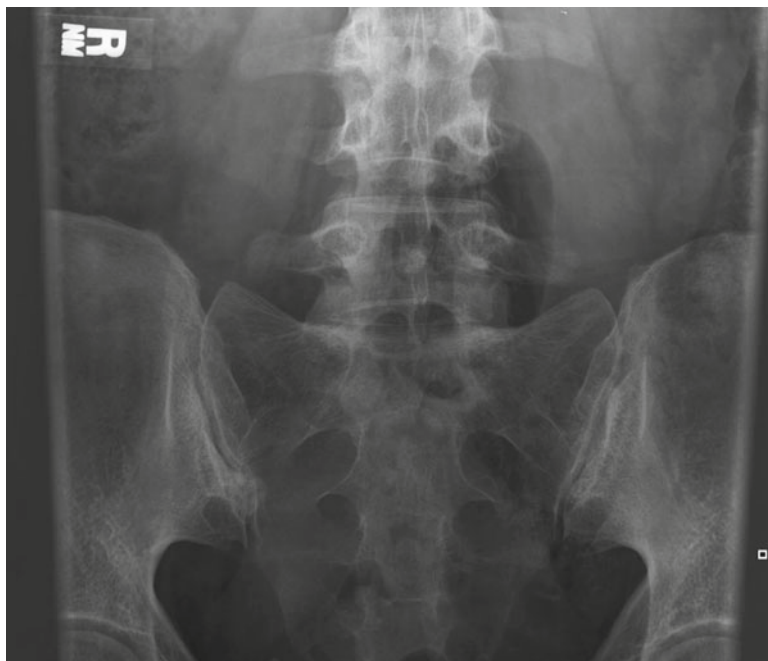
Radiograph of SI joints with Ferguson view in a patient with psoriatic arthritis demonstrating erosive changes of the right sacroiliac joint
